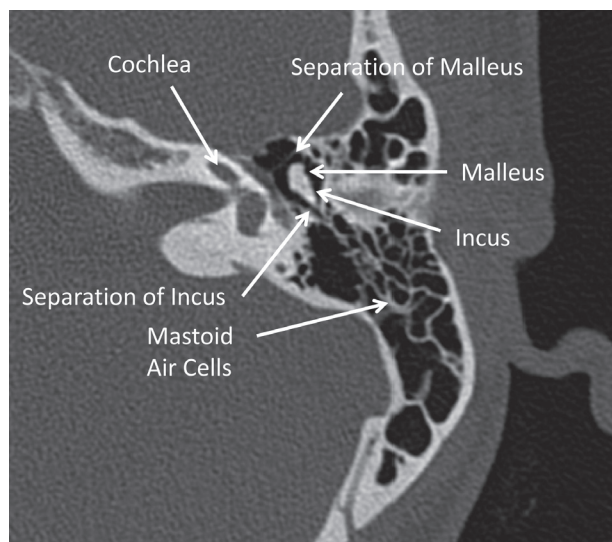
This image of a normal temporal bone shows a clear separation between the malleus and the epitympanum, as well as between the incus and the scutum/mastoid. On CT images, note that bone is white, air is black, and soft tissue is gray.
